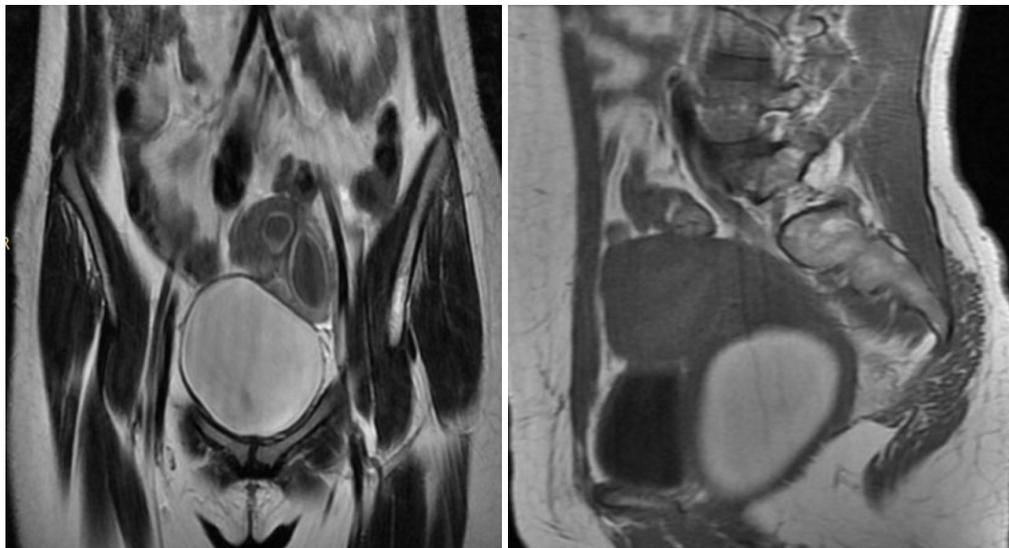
T2W coronal and T1W sagittal MRI images showing distended left hemivagina showing T2, T1 hyperintense signal suggestive of hematocolpos. Two distended uterine cavities with mildly T1 hyperintense signal suggestive haematometra are also seen.
